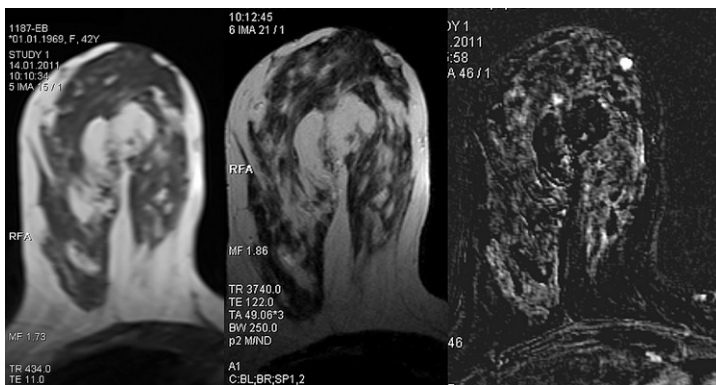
MRI appearances of a periareolar papilloma with a dimension of 5 × 6 mm.
